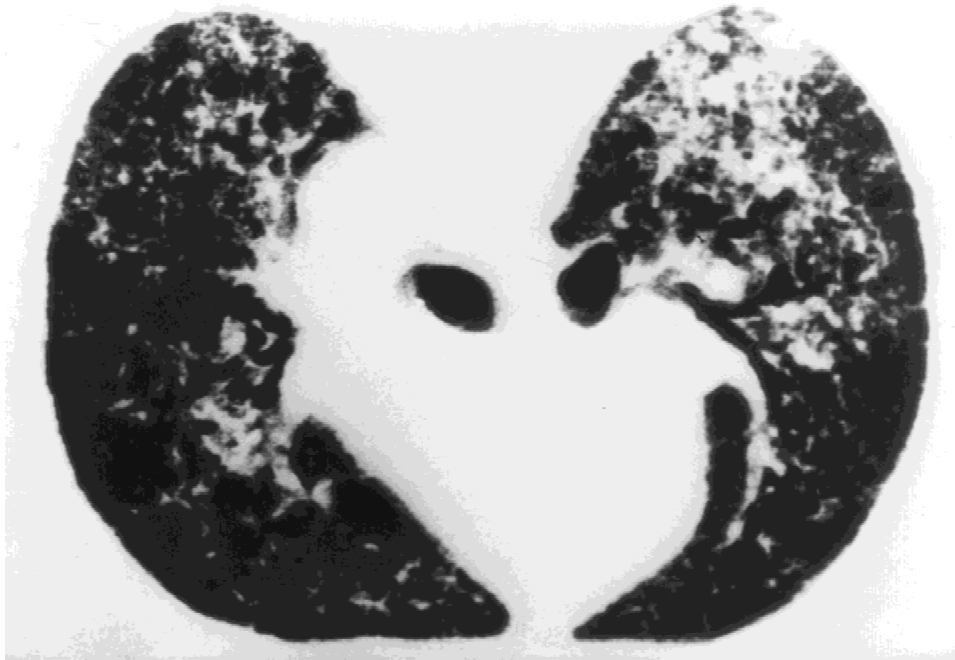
CT scan of the chest showing diffuse intraalveolar and interstitial infiltrates.
